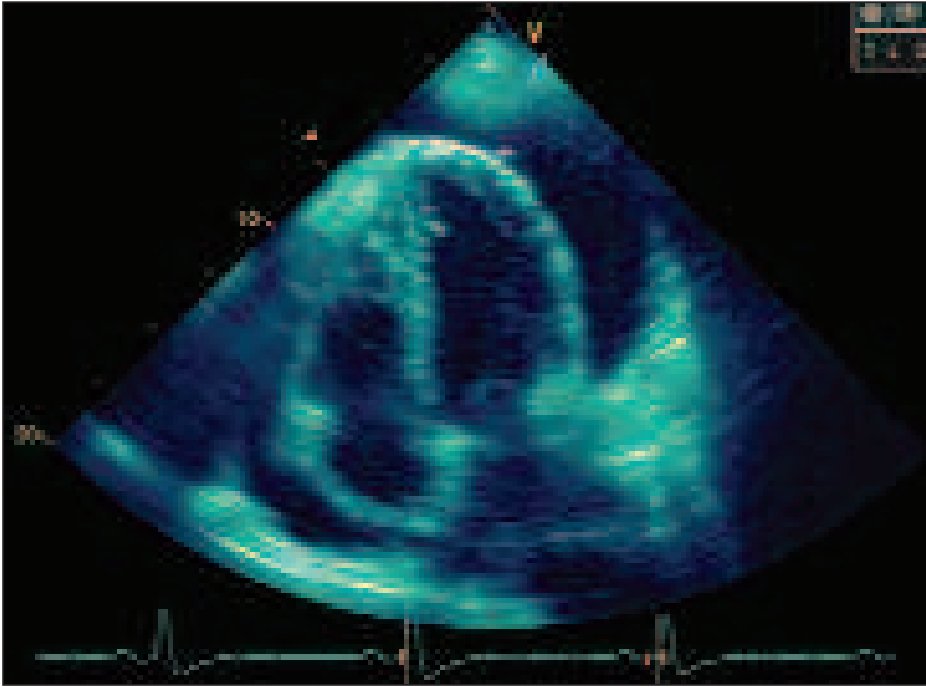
Pericardial Effusion An echocardiogram showing pericardial effusion typically seen in association with pericarditis.
